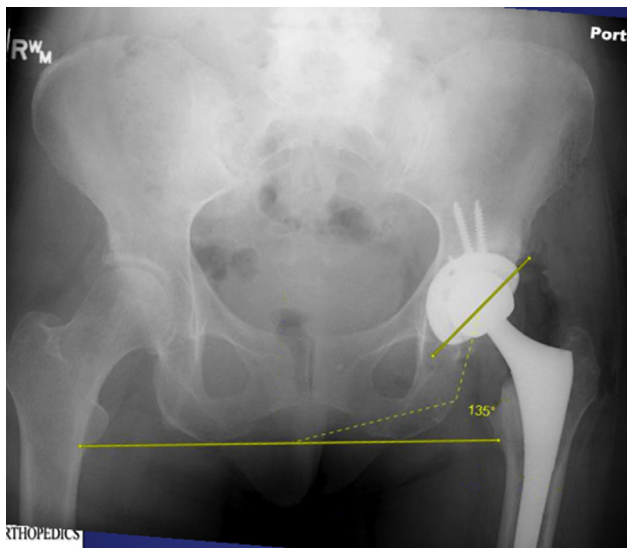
Immediate postoperative anteroposterior pelvis radiograph of case 2 with appropriate placement of the components and bone augments.
